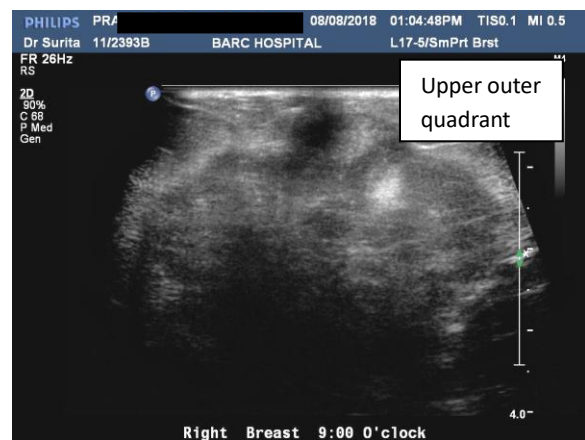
Ultrasonography showing heteroechoic irregular lesion, 5.7x3.5 cm in size with angular margins in upper and outer quadrant at 10 o'clock position
